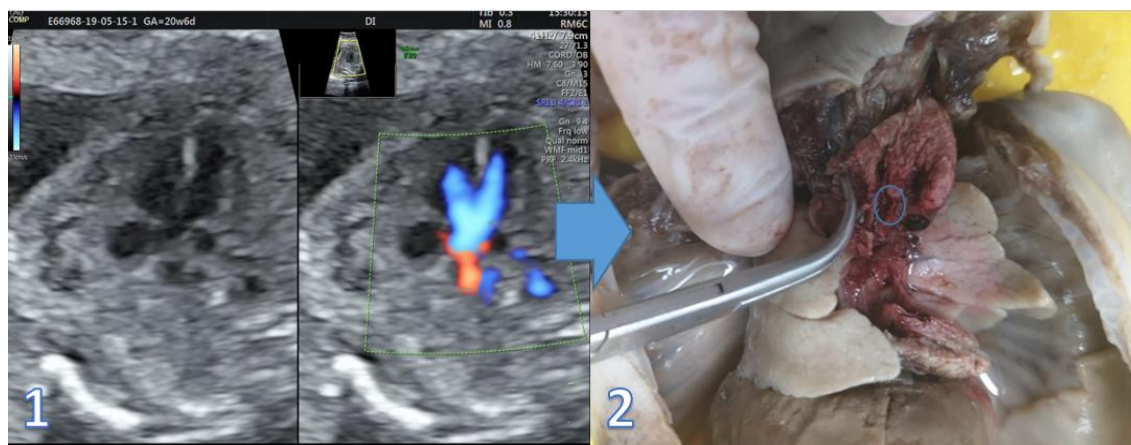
Ultrasound examination in the second trimester of the same fetus. Membranous VSD was suspected (1) and confirmed at the autopsy (2) (the family choose medical termination of the pregnancy as the fetus associated ventriculomegaly, unilateral renal agenesis, persistent cystic hygroma, single umbilical artery, small stomach and suspicion of anal atresia).
